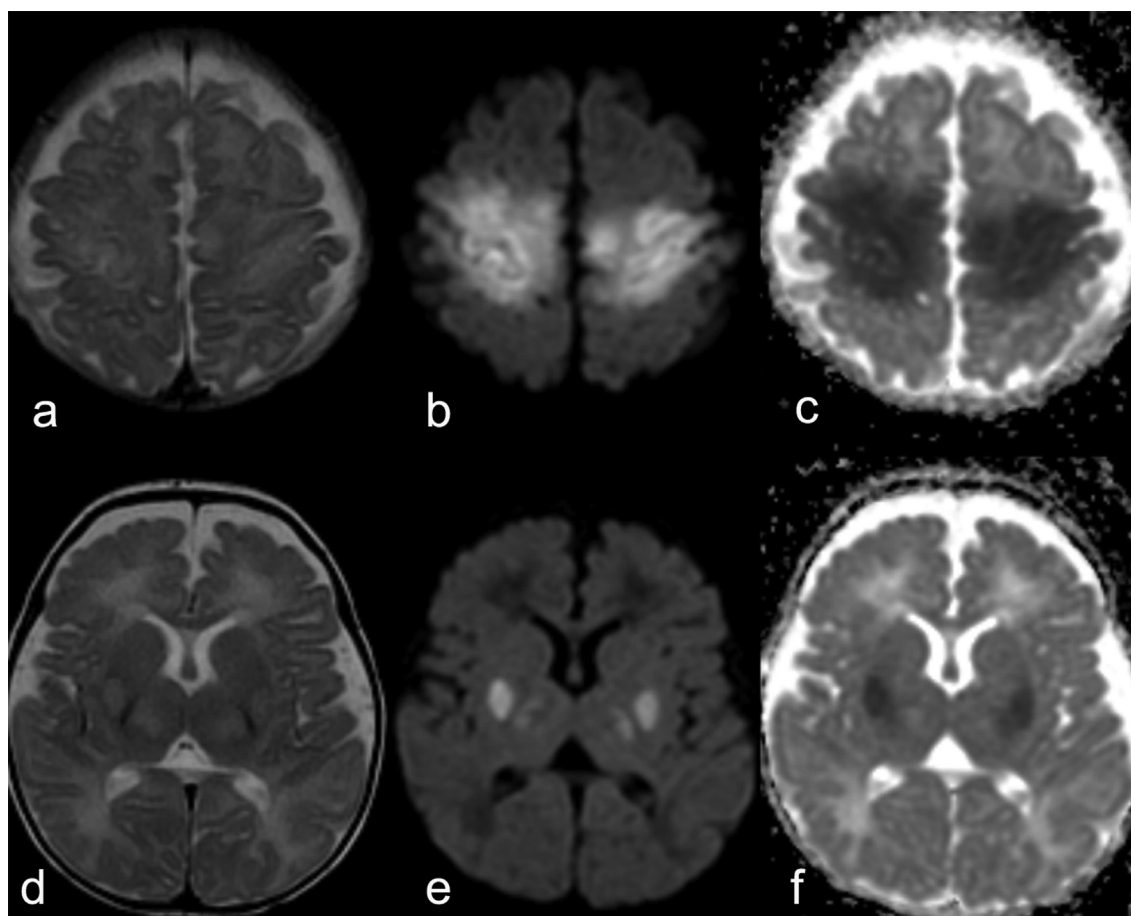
Axial T2-weighted MR images (a, d) show increased signal intensity in bilateral perirolandic area, lateral thalami and posterior putamina. There is restricted diffusion on DWI (b, e) and ADC map (c, f) in the same areas.
